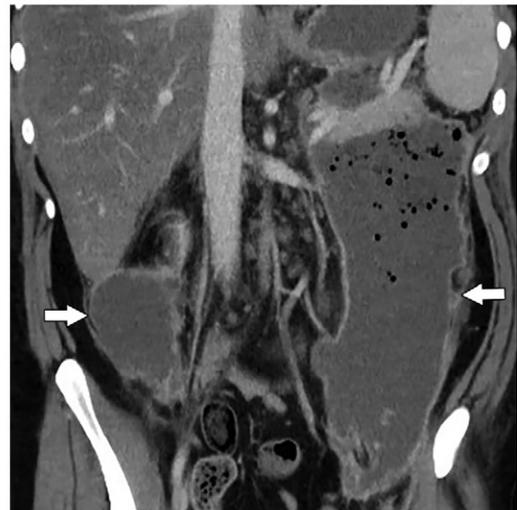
Infected WON on contrast-enhanced coronal CT scans in a 25-year-old man with idiopathic pancreatitis. (a) On day 7 after symptom onset, extensive bilateral ANCs are visible in the pararenal spaces. The ANCs extend to the pelvis (*), demonstrate heterogeneous fluid attenuation, and contain nonliquefied debris, including fat globules (arrows). (b) On day 15, the collection (*) has a more organized appearance, and it is easier to identify necrotic fat in the collection (arrow). (c) On day 42 image obtained after readmission for sepsis, organized, heterogeneous, gas-containing collections with thick enhancing walls are present in the pararenal space (arrows), findings that are consistent with infected WON.
